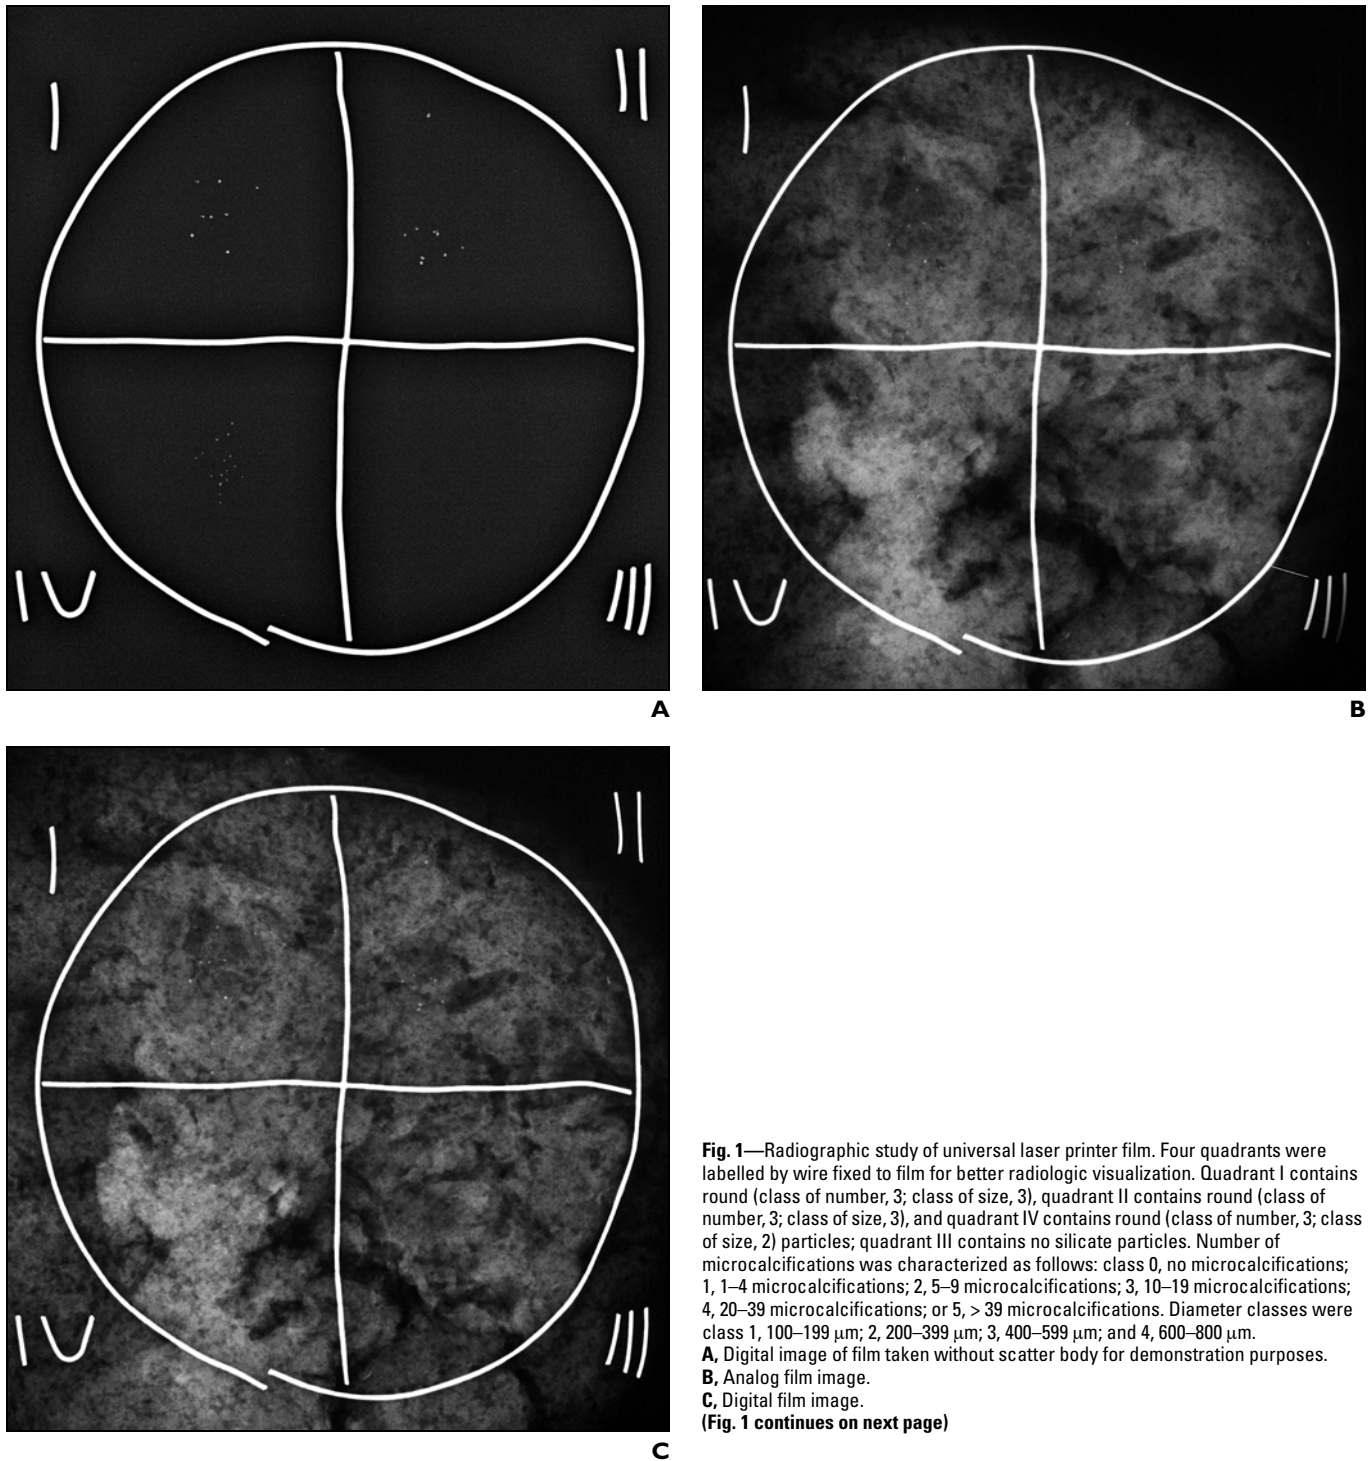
Radiographic study of universal laser printer film. Four quadrants were labelled by wire fixed to film for better radiologic visualization. Quadrant I contains round (class of number, 3; class of size, 3), quadrant II contains round (class of number, 3; class of size, 3), and quadrant IV contains round (class of number, 3; class of size, 2) particles; quadrant III contains no silicate particles. Number of microcalcifications was characterized as follows: class 0, no microcalcifications; 1, 1–4 microcalcifications; 2, 5–9 microcalcifications; 3, 10–19 microcalcifications; 4, 20–39 microcalcifications; or 5, > 39 microcalcifications. Diameter classes were class 1, 100–199 μm ; 2, 200–399 μm ; 3, 400–599 μm ; and 4, 600–800 μm .
